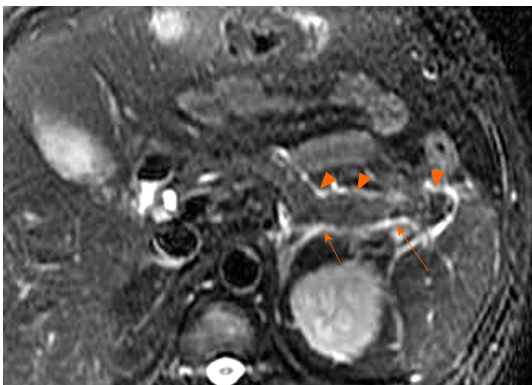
A 40-year-old woman with interstitial oedematous pancreatitis. Magnetic resonance imaging axial T2WI image shows uniform linear liquid hyperintense (acute peripancreatic fluid collections) in the left pararenal anterior spaces (arrowheads) and retromesenteric plane (arrows).
